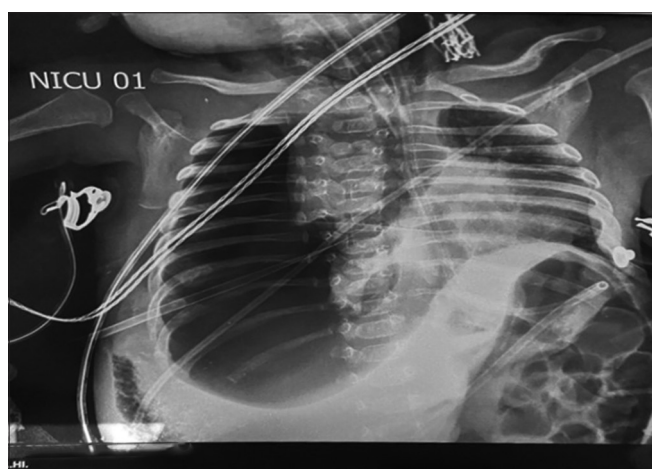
Chest X-ray showing massive right-sided pneumothorax with mediastinal shift to the left.
